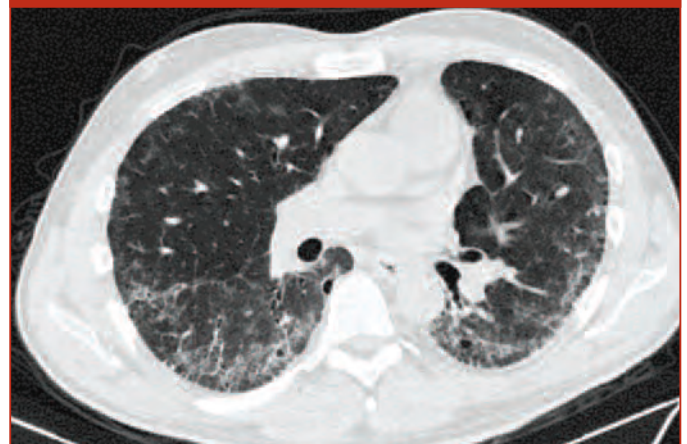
HRCT on 1/7/10 at the bases of the lung.
